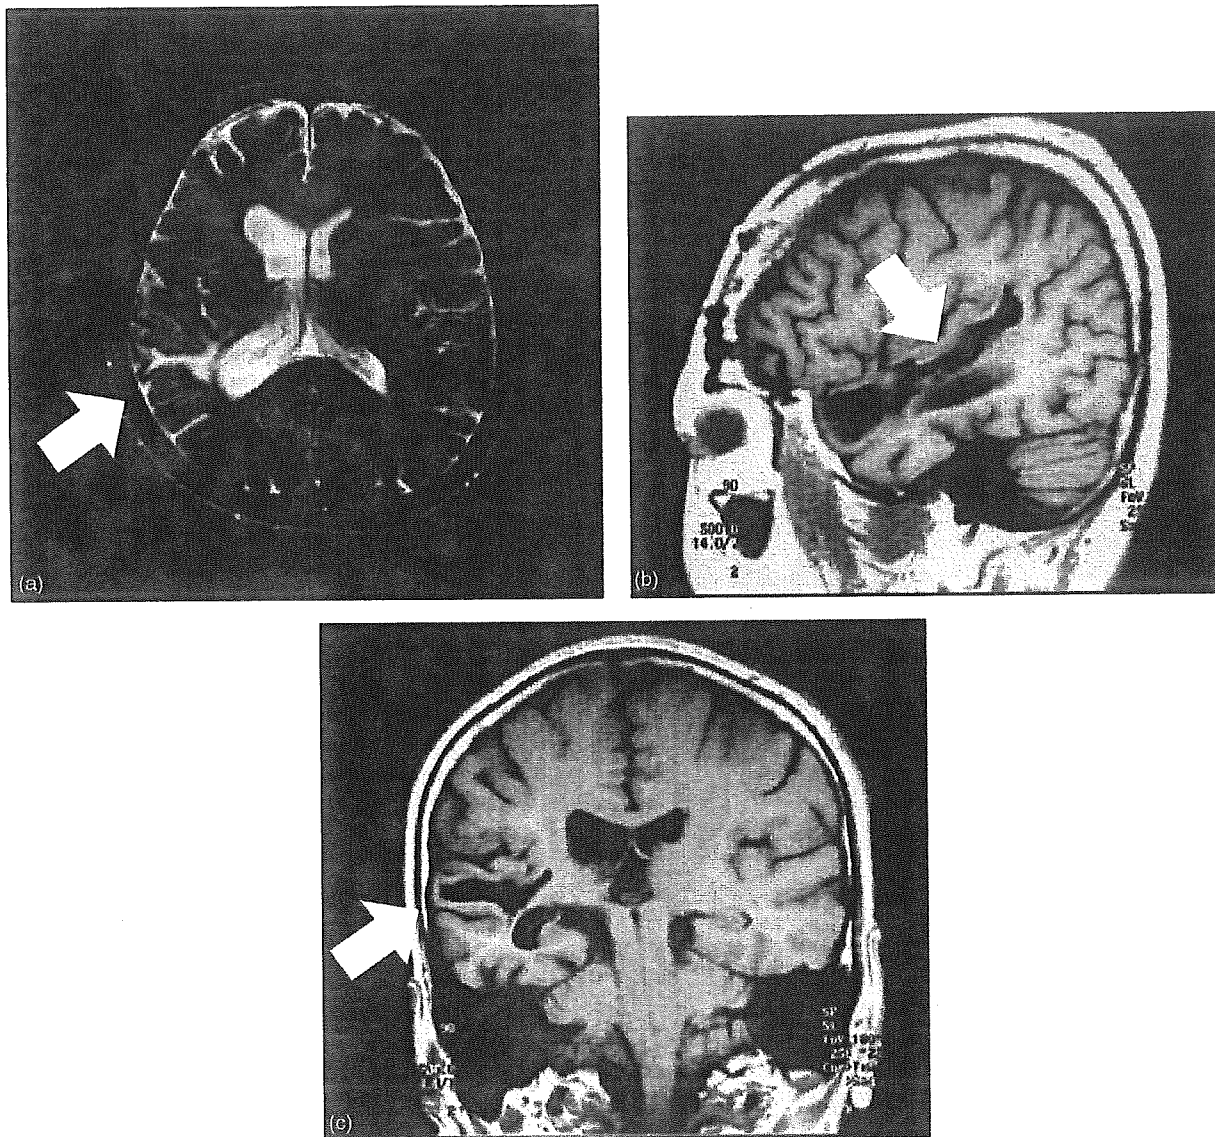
MRI scan 2 years post onset. A rare lesion almost completely circumscribed to the entire STG, which is indicated by the arrows, is shown in the (a) axial, (b) sagittal, and (c) coronal slices. A moderate atrophy of the right medial temporal lobe can also be observed in the coronal slice.
